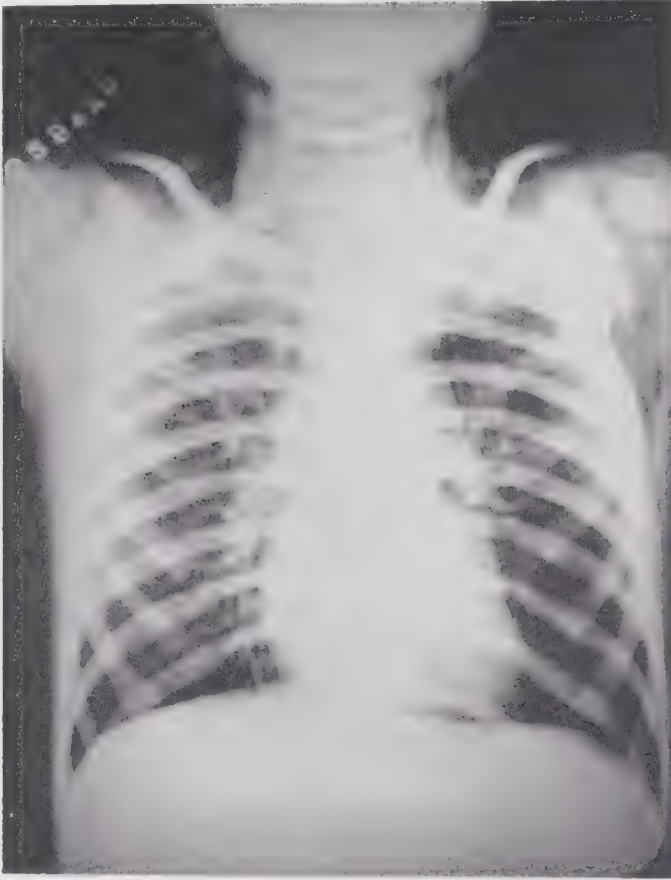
Roentgenogram of a five year old boy showing widespread mediastinal emphysema, emphysema extending to the neck and face, emphysema about the pericardium and some tracheal compression. From Kahn and Rouse (15).
